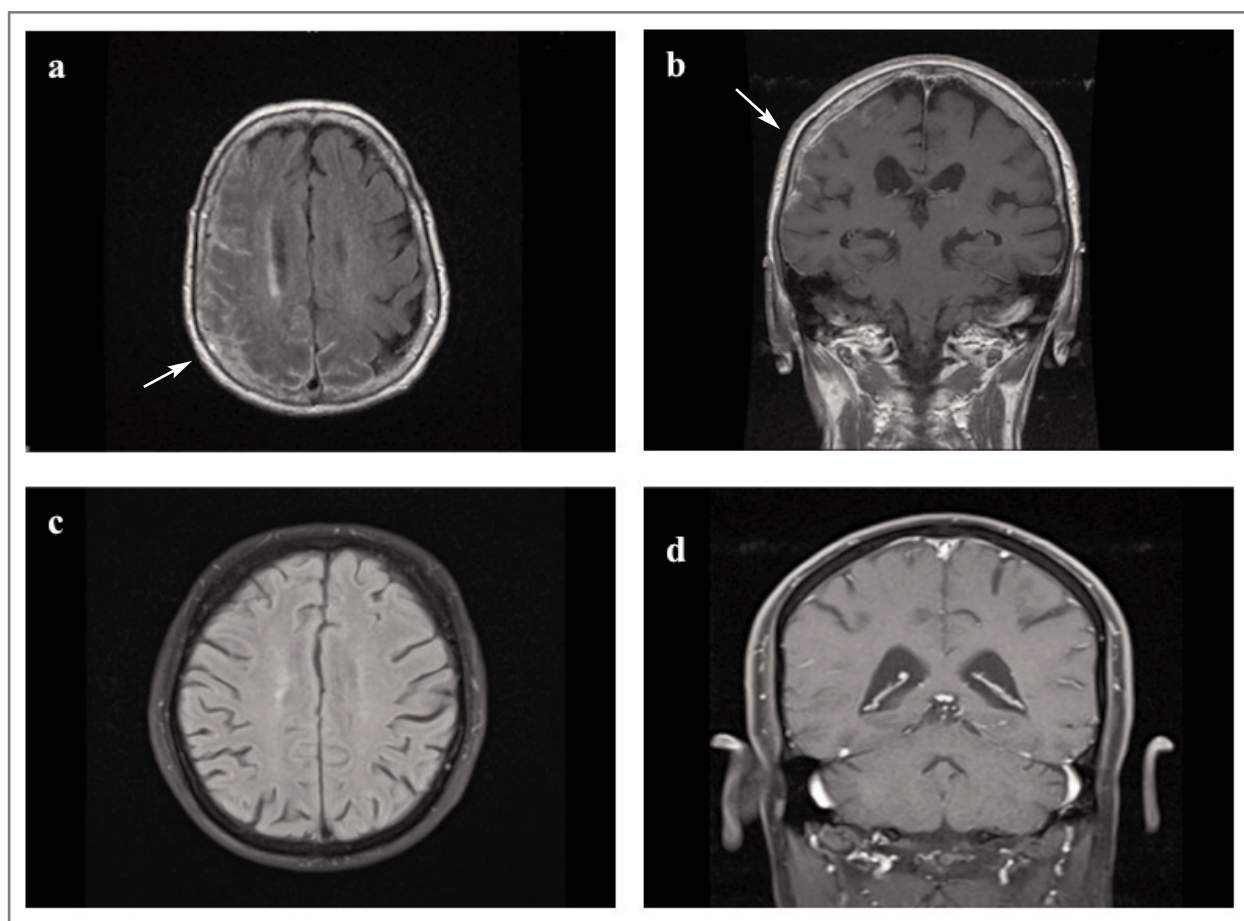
Brain magnetic resonance imaging (MRI) before and after rituximab (RTX) therapy. a) Axial T2 flair and b) Coronal T1 pos gadolinium, both images regarding brain MRI before RTX therapy showing increased leptomenigeal and dural thickening with worsening of leptomenigeal enhancement over the left posterior parietal lobe. c) Axial T2 flair and d) Coronal T1 pos gadolinium, both images regarding brain MRI one year after RTX therapy, showing no alterations.
